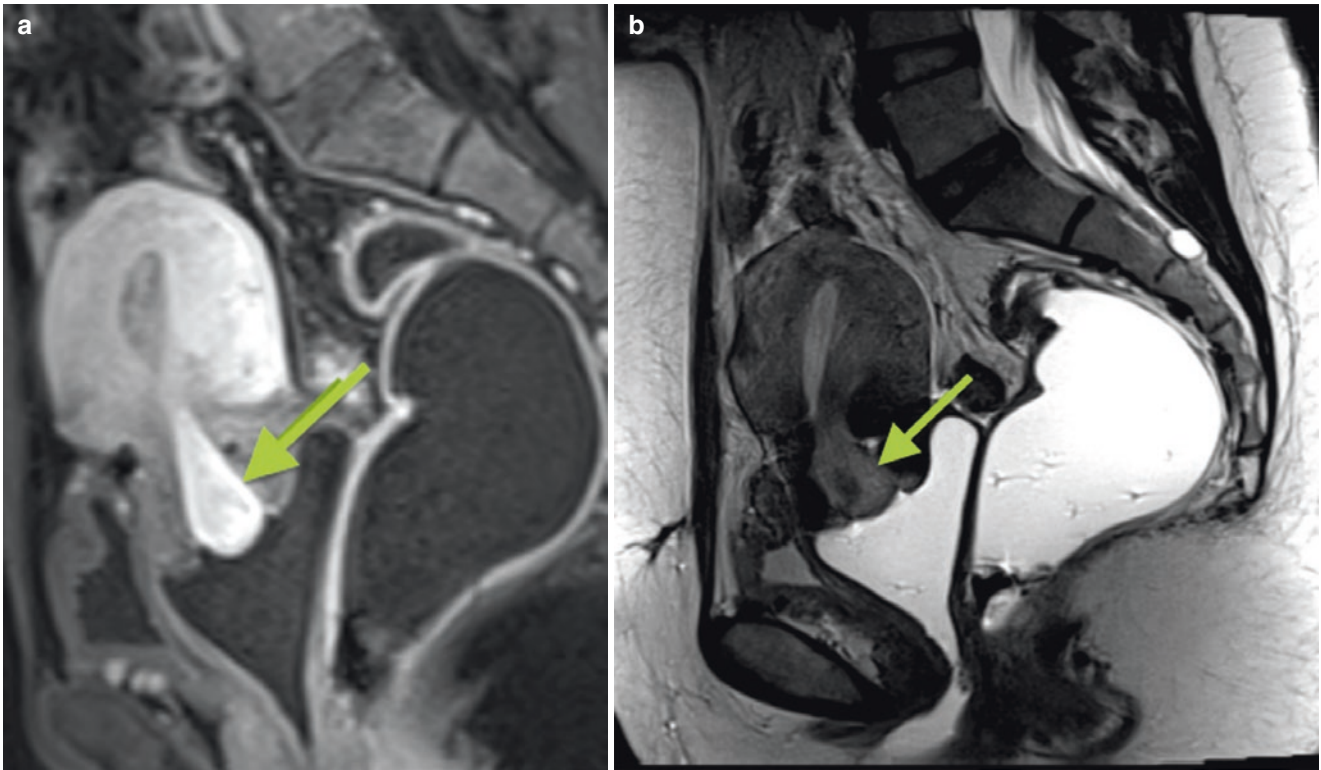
Submucosal myoma. (a) Pelvic MRI, weighted in T1 after contrast injection (sagittal section), showing nodule with hypersignal (*arrow*), occupying endocervical canal, and extrauterine portion. (b)
